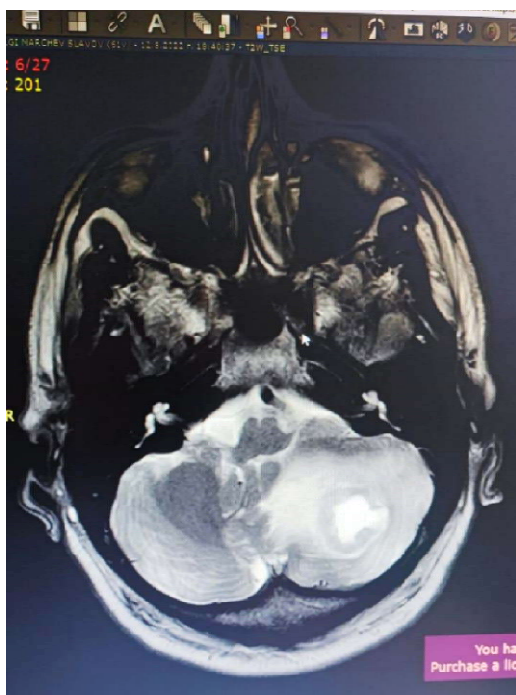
MRI, Patient 1, before surgery
